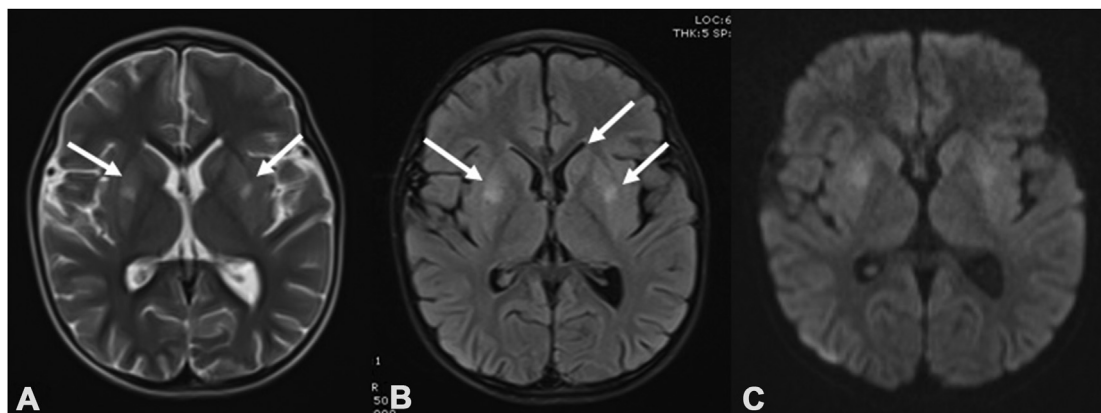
In the cranial MRI examination of the case 12 days later, it is observed that edema and pathological signal changes at the level of bilateral caudate and lentiform nuclei have decreased significantly.
